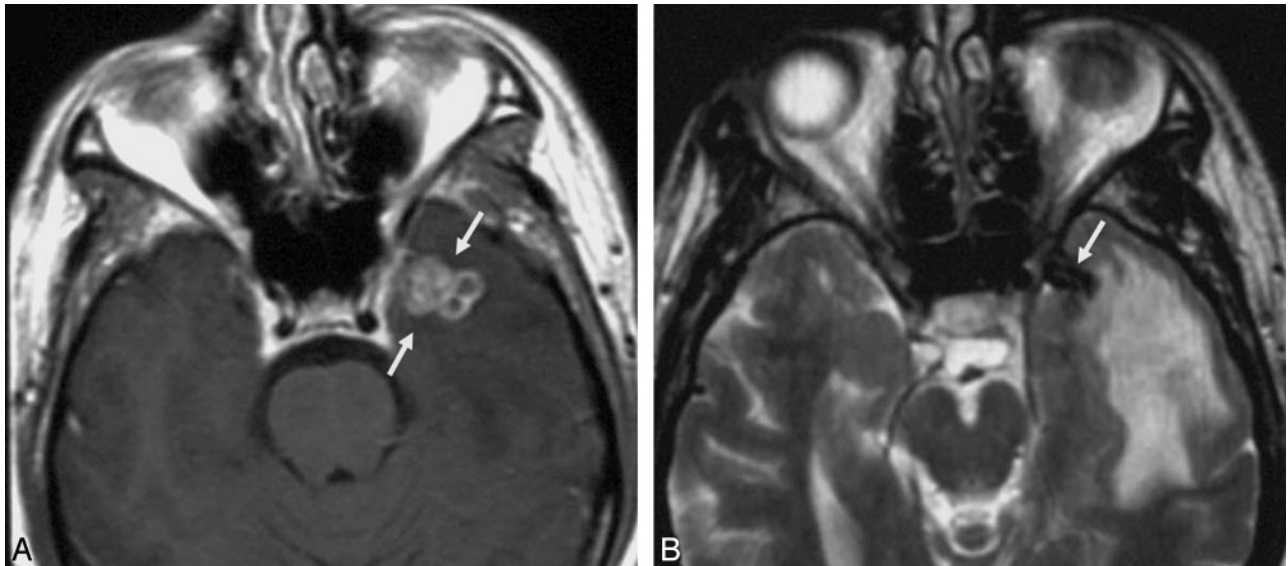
Axial MR images obtained at the level of the temporal lobes. T1-weighted postcontrast image (A) shows a rim-enhancing, multilocular masslike lesion within the anterior left temporal lobe (arrows). The enhancement corresponds to the chronic granulation tissue surrounding the foreign body. FSE T2-weighted image (B) shows surrounding confluent T2-hyperintense vasogenic edema. Susceptibility effect (arrow) was preoperatively thought to reflect old blood products (hemosiderin) but most probably was the foreign body itself (likely fiberglass, according to the surgeon).
